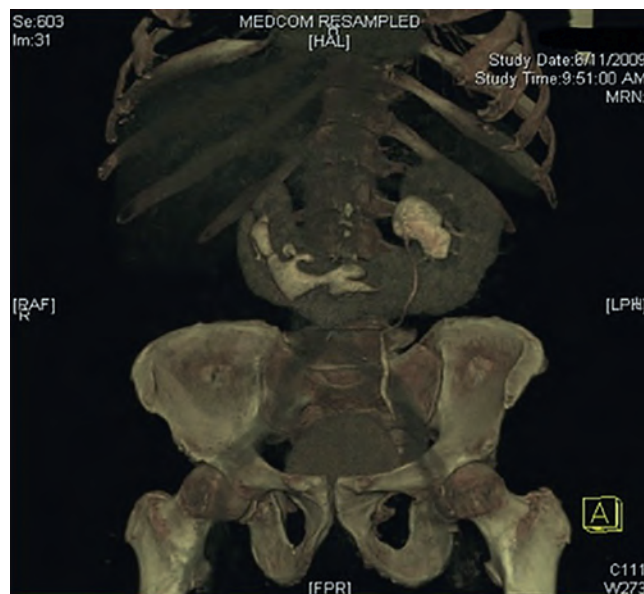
Three-dimensional computed tomographic reconstruction of horseshoe kidney with bilateral staghorn calculi. Note the medial and inferior position of the horseshoe kidney. (From Tan YK, Cha DY, Gupta M. Management of stones in abnormal situations. *Urol Clin North Am* 2013;40:79–97.)
